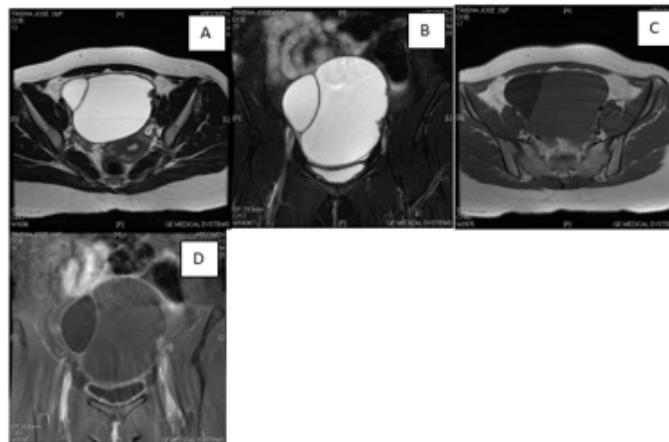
MRI Imaging of an Ovarian Lesion
